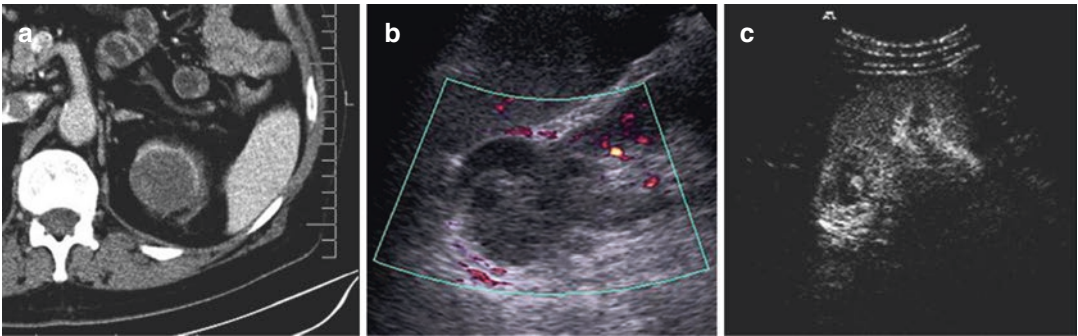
Contrast enhancement CT scan shows a complicated cystic lesion with diffuse and smooth contrast enhancement (a). Color Doppler examination demonstrates a heterogeneous mass with hypoechoic and fluid
